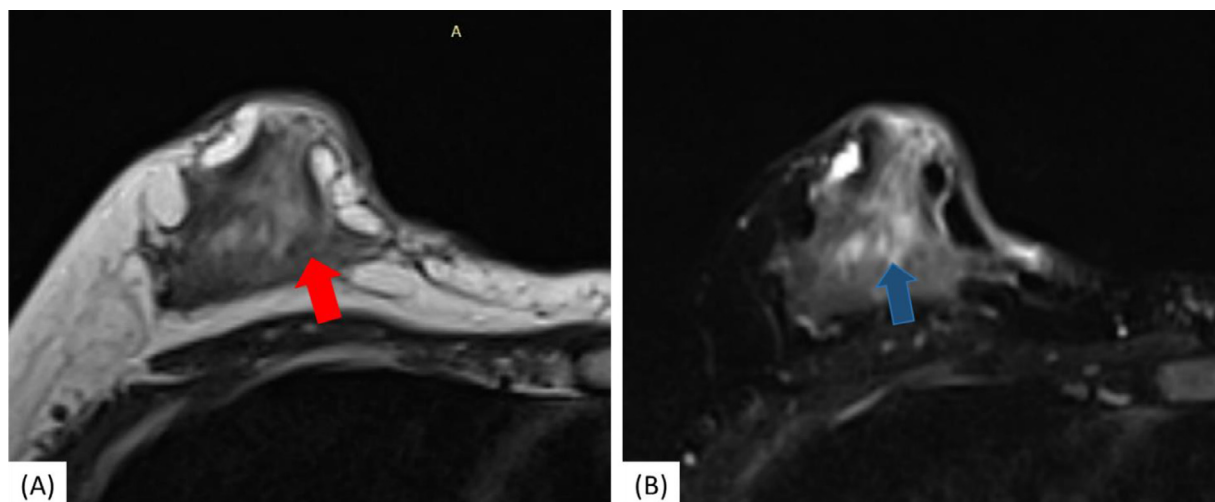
Axial T2-weighted MR image (A) and axial fat-suppressed T2-weighted (B) of the right breast with DIY silicone rubber blend. The injected material showed an unclear limit and heterogeneous distributed area: hypointense on T2-weighted (red arrow) and hyperintense on fat-suppressed T2-weighted image (blue arrow).
